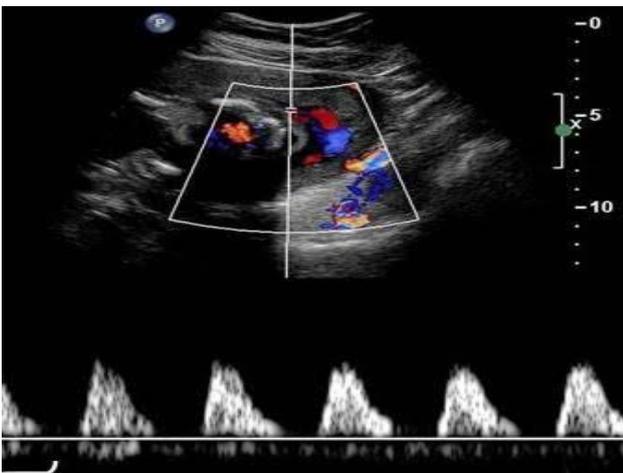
Umbilical artery doppler with absent diastolic flow.
